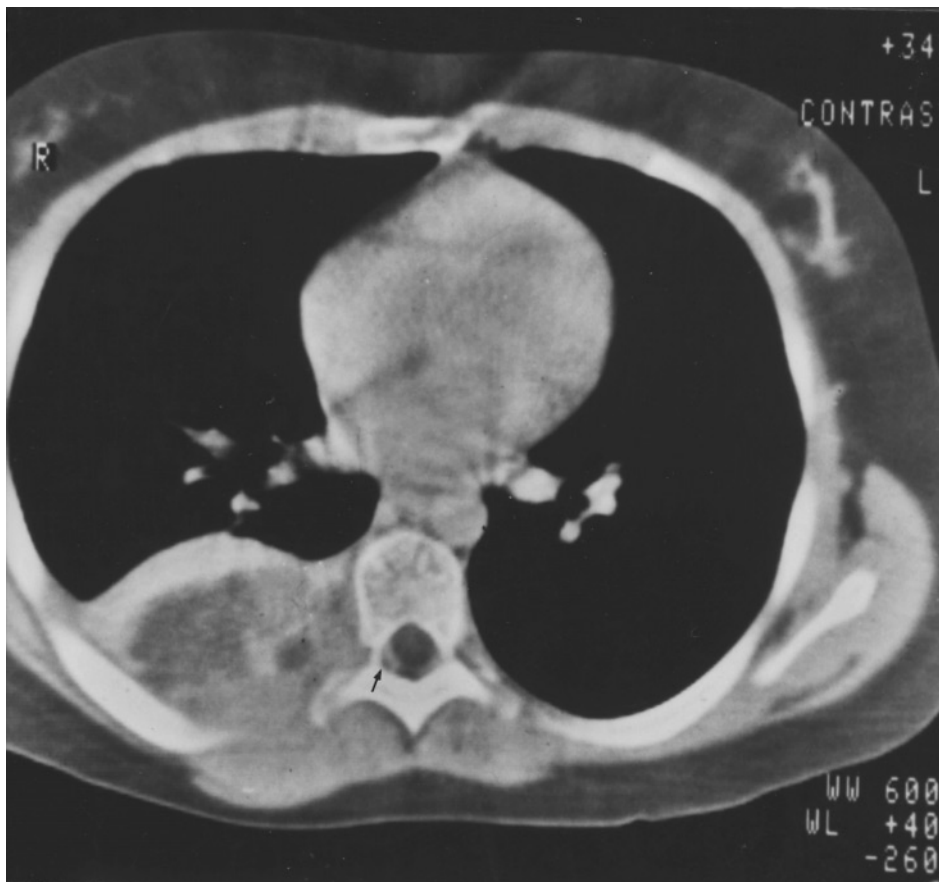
CT scan of original tumour: Ewing sarcoma of right 7th rib with large soft tissue mass in the posterior thorax and early protrusion into the spinal canal (arrow).
